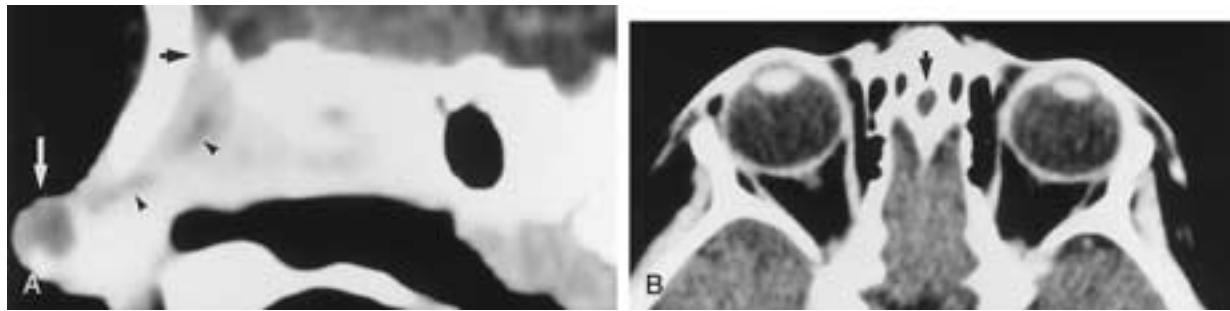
Dermal cyst the nasal tip. A, Sagittal reformatted CT. The lucent dermoid cyst (white arrow) at the nasal tip connects via a lucent track (black arrowheads) to an expanded foramen cecum (black arrow). B, Axial CT confirms the expansion of the foramen cecum (arrowhead).
